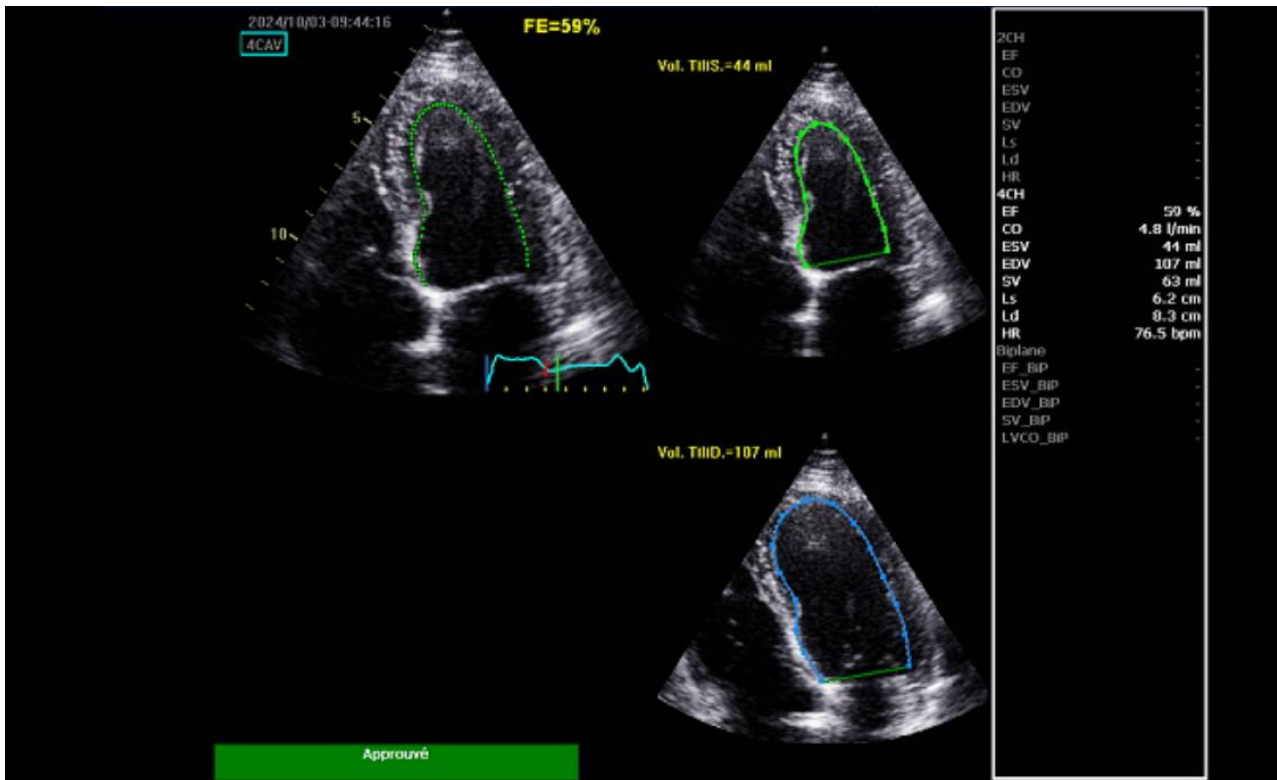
Recent echocardiography demonstrates an improvement in the left ventricular ejection fraction (LVEF), increasing from 26% to 59% following revascularization
